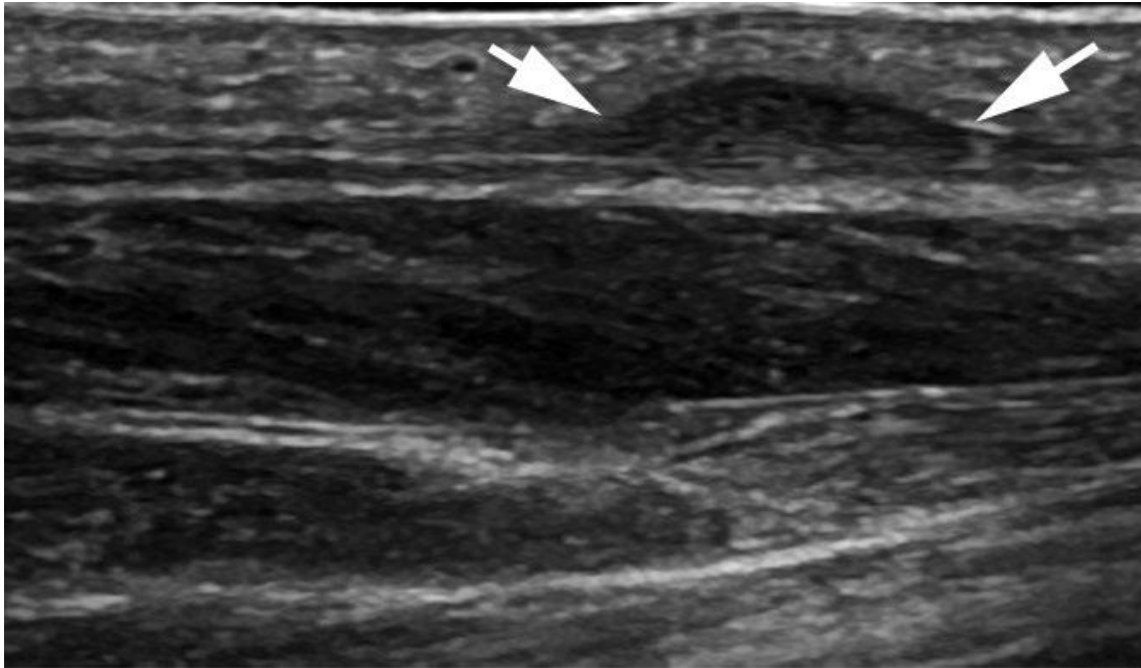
Plantar fibroma seen as a fusiform hypoechoic mass arising from the plantar fascia. Image adapted from a study by Claire Filippini, 2019 on Ultrasound features of the sole of foot pathology (14)
